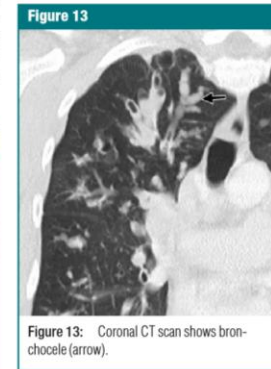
Coronal CT scan shows bronchocele (arrow).
